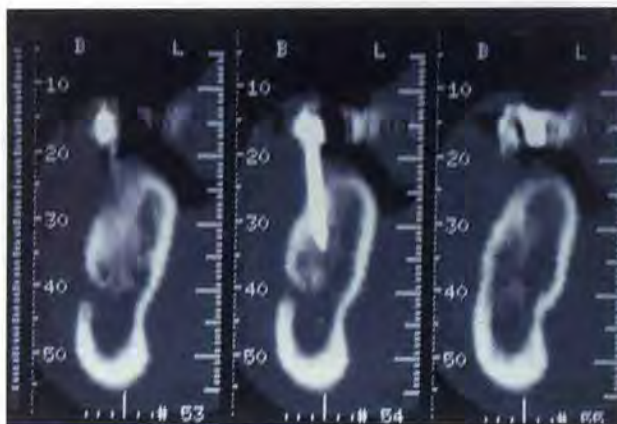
Computerized tomography scan performed with radiographic template demonstrates transitional implant placed labial and mesial to conventional implant site marker.
